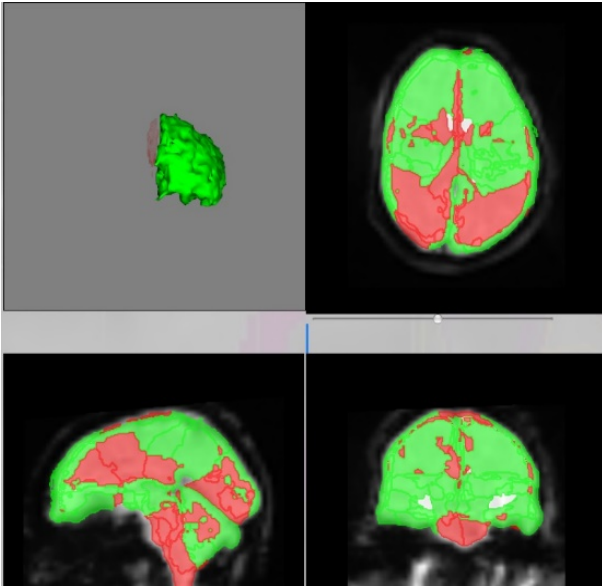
Axial, coronal and sagittal MRI-Cloud image of a patient.
